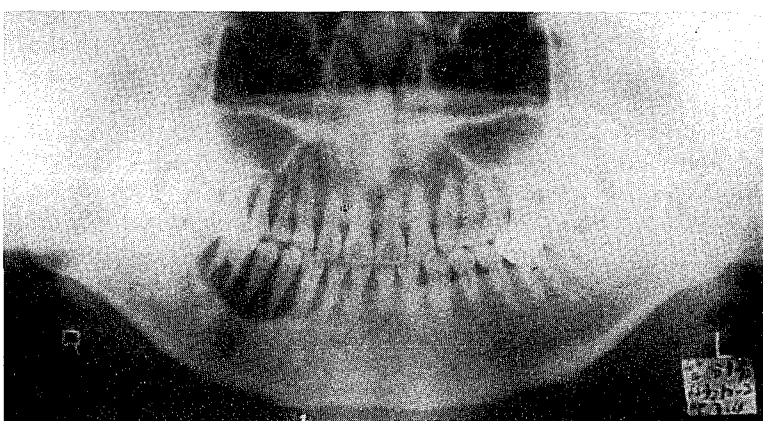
Panoramic radiograph showing the osteolytic lesion at the right mandibular posterior teeth. The appearance is suggestive of the customary description of "teeth suspended in space; hanging in air".
